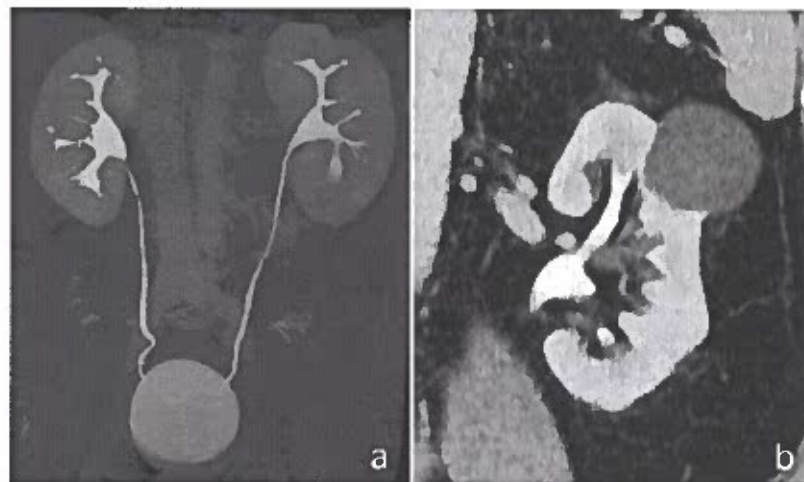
Computed tomography urography (CTU): MIP (maximum intensity projection) (a) and coronal (b) images. Furosemide administration allows distention of the entire urinary tract, without blooming artifacts due to high attenuation of intraluminal contrast medium; the split-bolus technique allows simultaneous luminal and parenchymal assessment.
